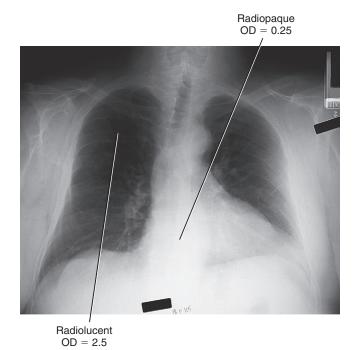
Relative radiolucency and optical density (OD) are shown on this radiograph. (Courtesy Bette Shans, Colorado Mesa University.)
